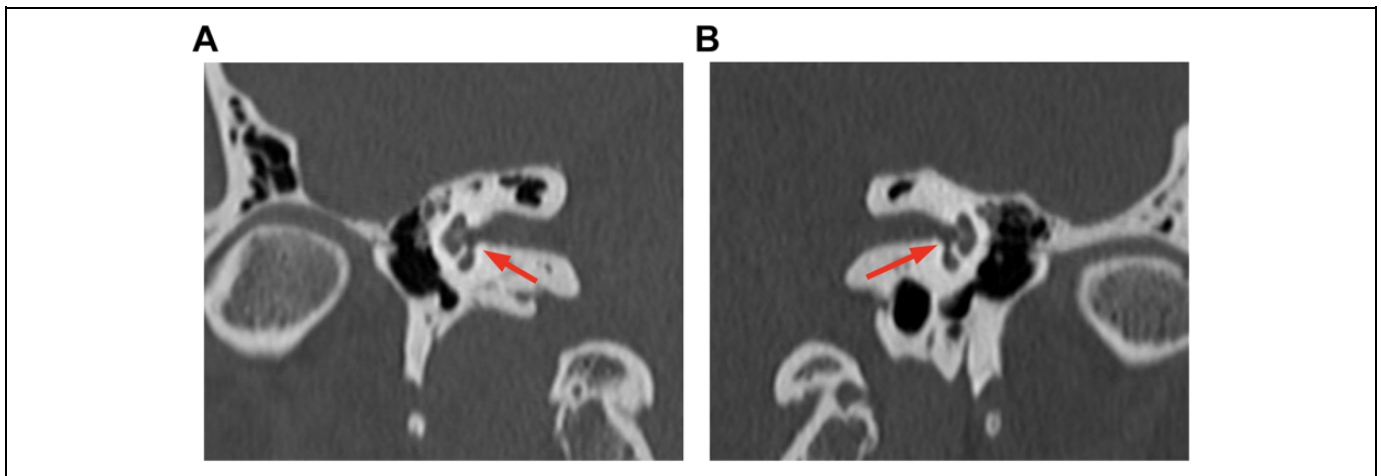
Reformatted computed tomography scan images in oblique planes, parallel to the long axis of the internal auditory canal and perpendicular to the long axis of the cochlear basal turn in the right (A) and left (B) side. The presence of an anomalous communication between the floor of the internal auditory canal fundus and the basal turn of the cochlea is bilaterally detected (red arrow). This bone defect represents in this case the anatomical basis of stapes gusher.
